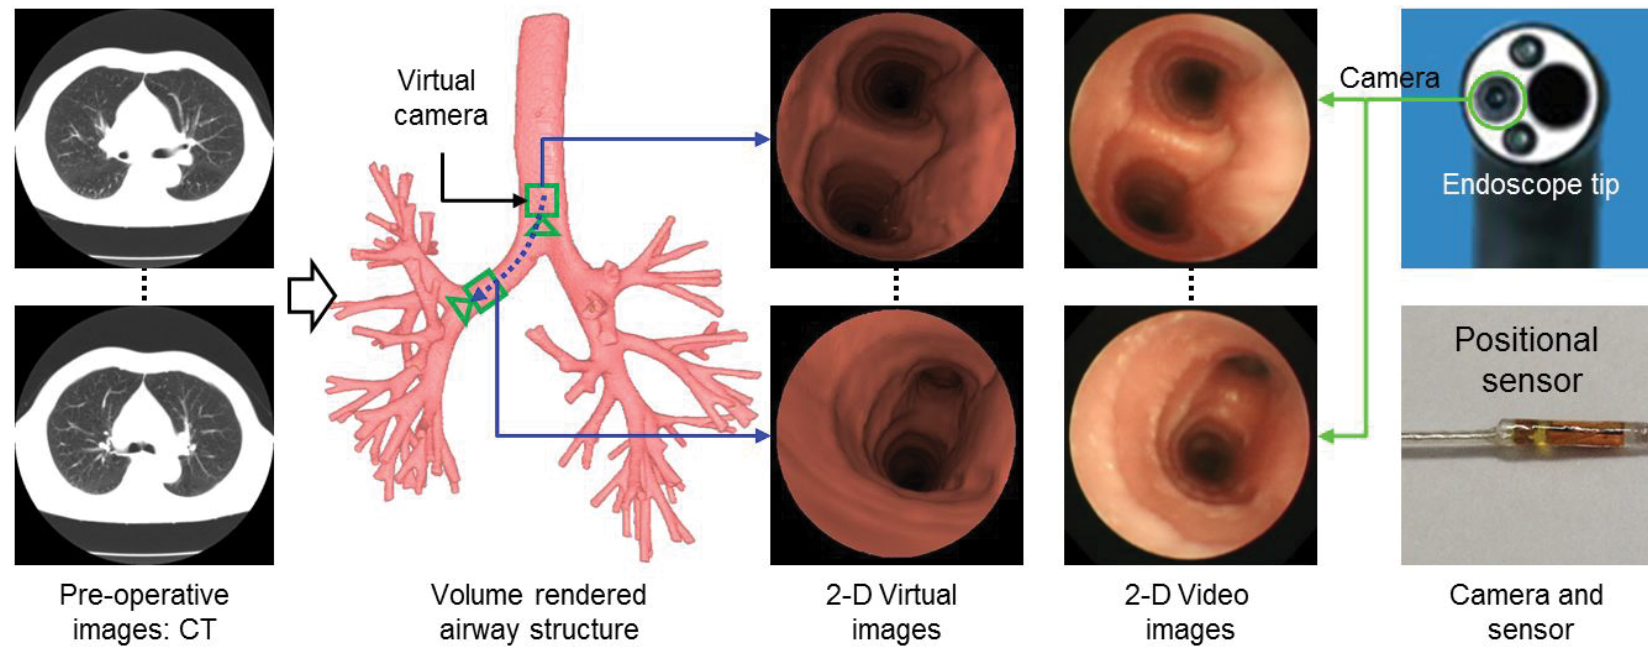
Multimodal information including the CT images used to generate 2-D virtual rendering images, endoscopic video images, and positional sensor measurements involved in an electromagnetically guided endoscopic procedure.
